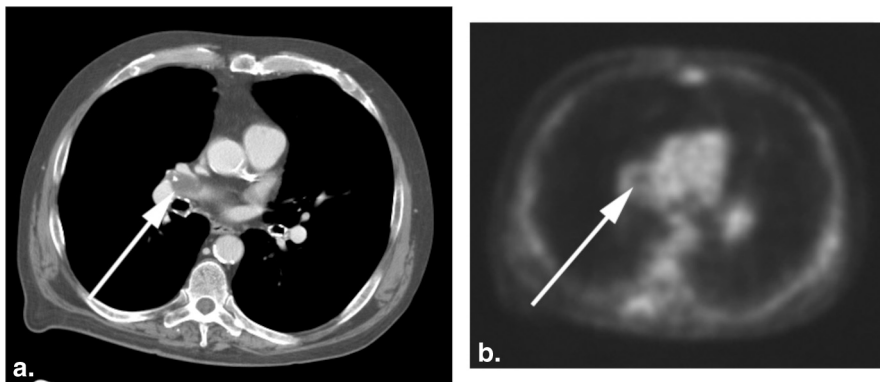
Example showing hypometabolism in chronic pulmonary embolism. A 66-year-old man with history of non-Hodgkin's lymphoma. (a) Contrast-enhanced CT demonstrates a calcified, eccentrically located filling defect in the right main pulmonary artery. This defect had been present on previous CTs and is consistent with a chronic pulmonary embolism. (b) The associated PET demonstrates a hypometabolic pulmonary arterial filling defect. CT, computed tomography; PET, positron emission tomography.
